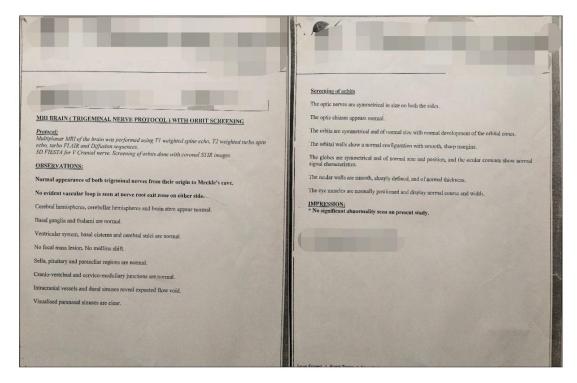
MRI report of brain
